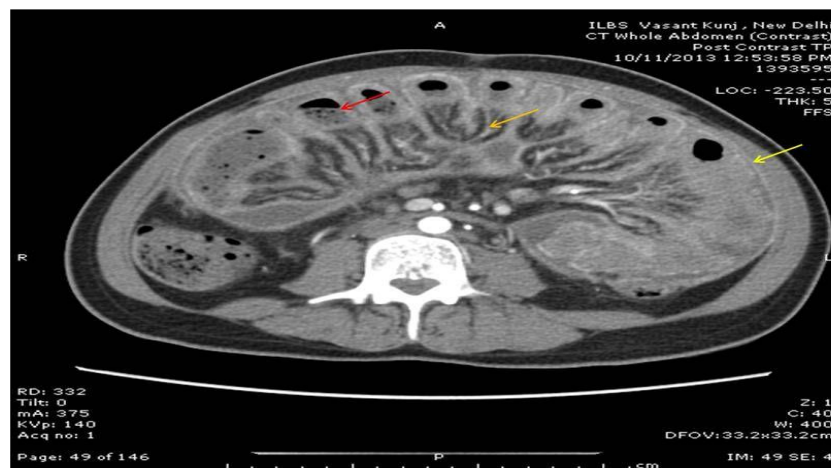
Contrast enhanced computed tomography of the abdomen showing the presence of enhanced peritoneal thickening forming a cocoon (yellow arrow); the 'small bowel feces sign' (red arrow) and the 'accordion sign' (orange arrow).
